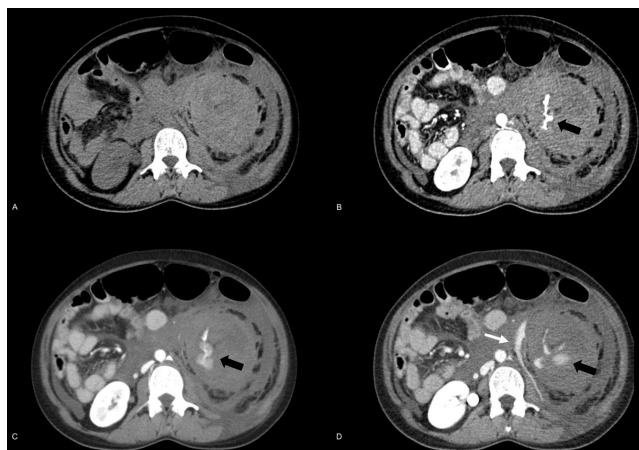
CTA Abdomen in plain (A), arterial (B), portovenous (C) and delayed (D) phases demonstrating progressive contrast pooling and 'blushing' within the left perinephric hematoma (black arrow) indicating active bleeding from the pseudoaneurysm and the ruptured tumour. Contrast tracking is seen in the pararenal space (white arrow)
